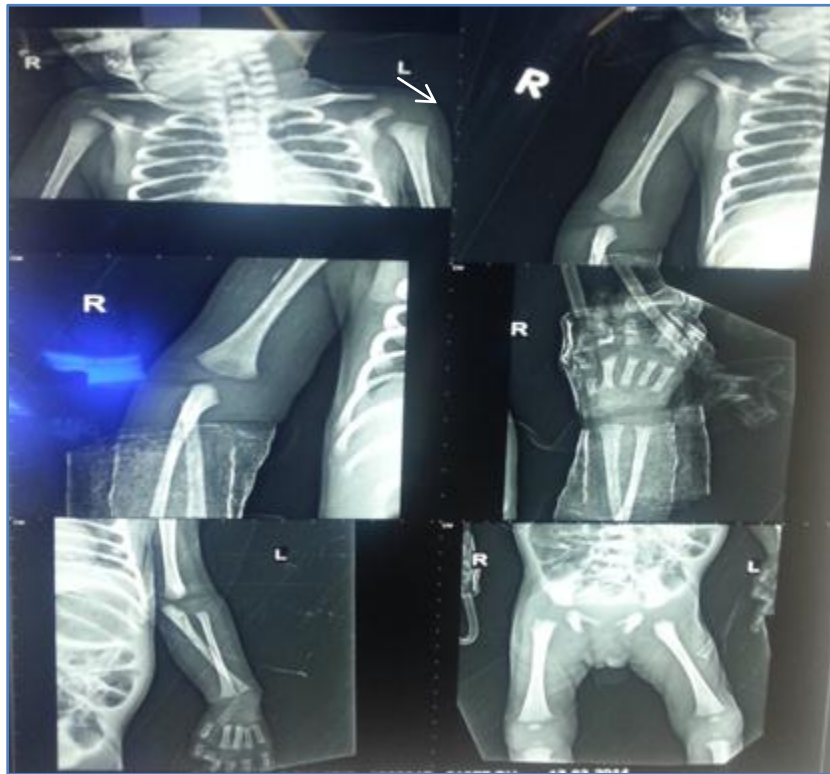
PHOTOGRAPHS OF X-RAYS SHOWING STIPPLING IN THE LONG BONES
